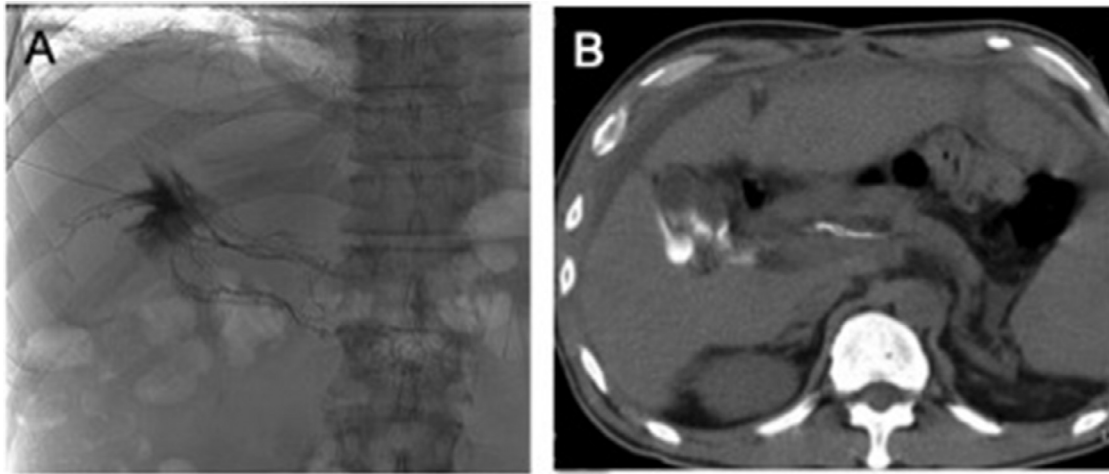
Case 2. Panel A: Transhepatic lymphangiography showing no abnormality. Panel B: Noncontrast abdominal CT-scan just after lymphangiography showing presence of intraperitoneal contrast.
